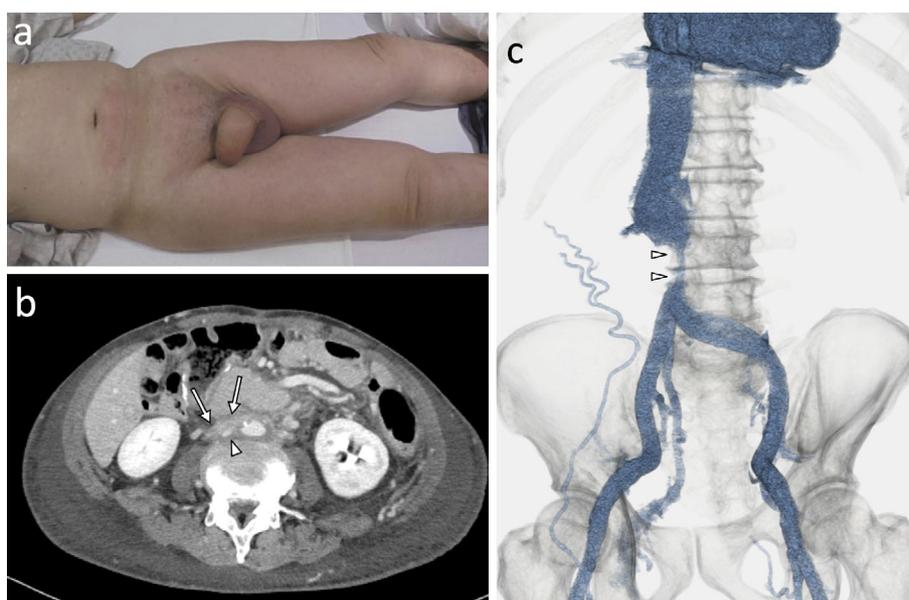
(a) Photograph before IVC stent placement showing severe hydrocele testis and bilateral leg edema. (b) Axial abdominal contrast-enhanced CT image showing the IVC surrounded by lymph node metastases (arrow), causing stenosis (arrowheads). (c) CT reconstruction venography showing severe stenosis of the IVC about 3 cm cranial from the confluence of the left and right common iliac veins (arrowheads).
